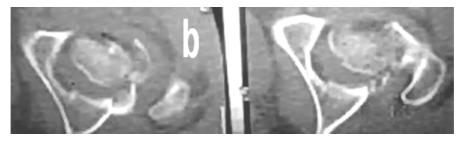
(a) -pre-operative AP radiograph of the Rt hip showing comminuted femoral head fracture around the tip of DHS screw used for old subtrochantric femoral fracture which was non united after 18 months.
